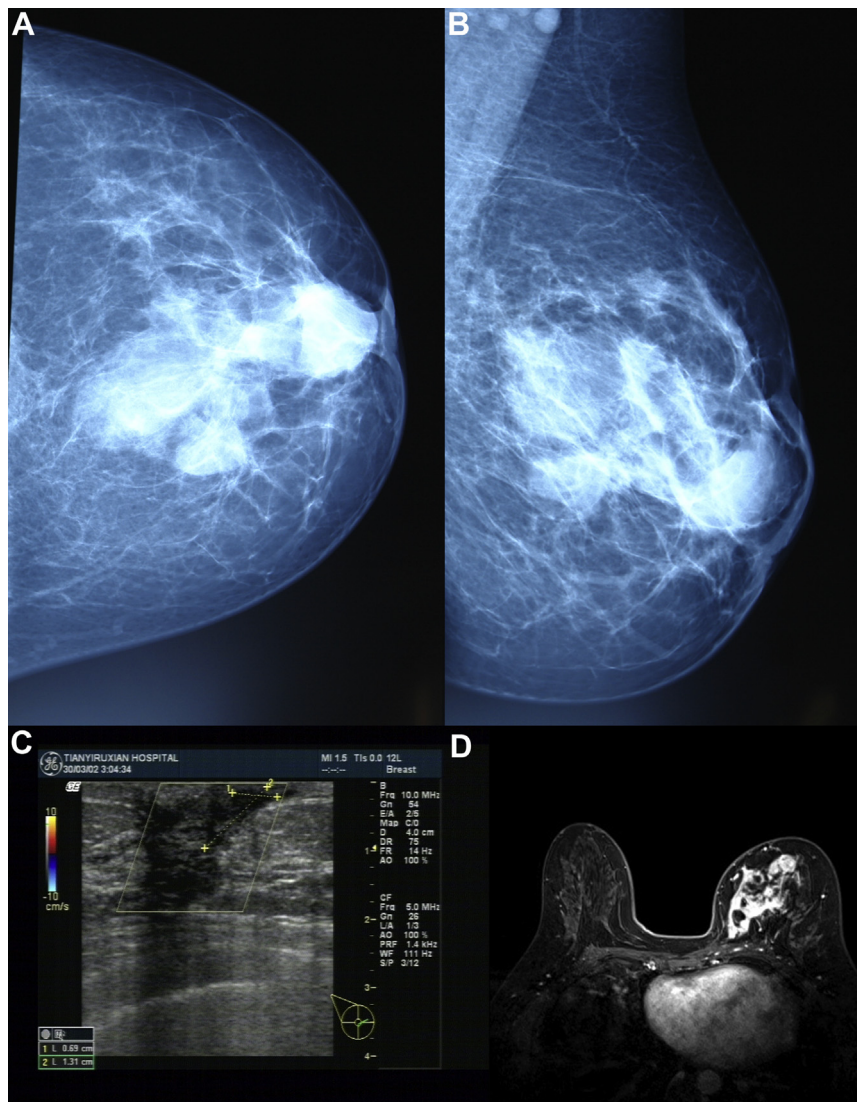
Axial (A) and (B) mediolateral oblique mammography, ultrasonography (C), and magnetic resonance imaging (D) of PDM.
